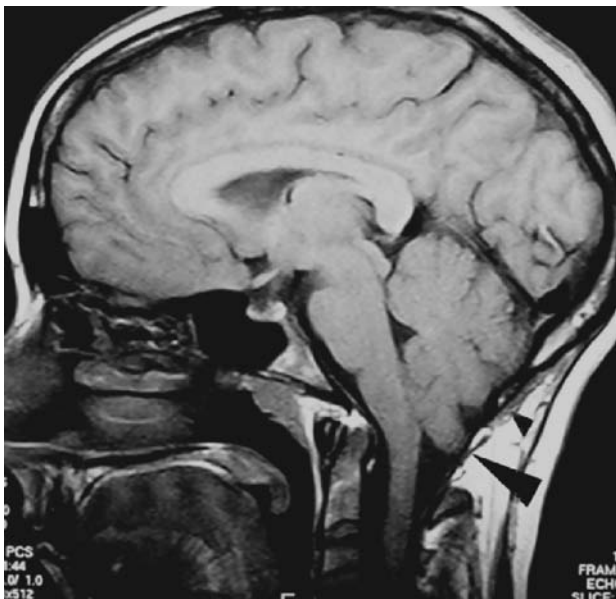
T1-weighted sagittal magnetic resonance imaging of a patient with a Chiari I malformation. The *large arrowhead* points to the cerebellar tonsils. The *small arrowhead* points to the posterior arch of the foramen magnum.
